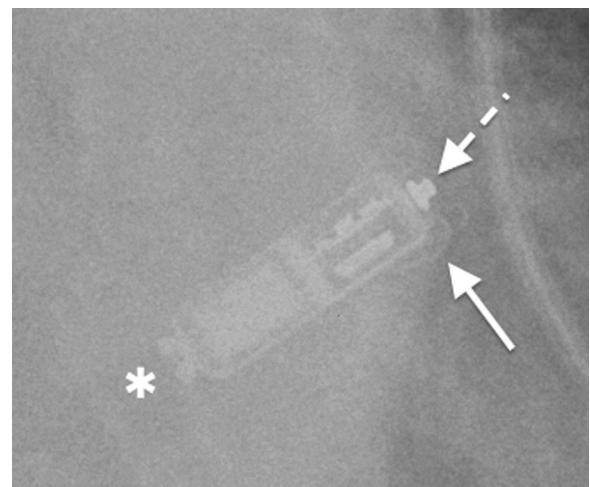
Chest radiograph (magnified view) with a Medtronic Micra device in situ. One of the self-expanding nitinol tines is clearly visible (solid arrow) as are the cathode (dashed arrow) and proximal retrieval feature (asterisk).
